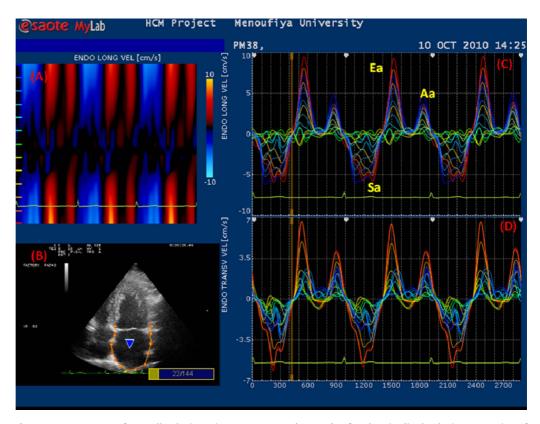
Assessment of LA wall velocity using VVI. A: Curved M-mode of LA longitudinal velocity. B: Tracing of the LA endocardial border in apical 4-Ch view showing velocity vectors. C: longitudinal. D: Transverse velocity—time curves from LA segments. (Sa: atrial systolic velocity, Ea: early atrial diastolic velocity, Aa: atrial late diastolic velocity).
